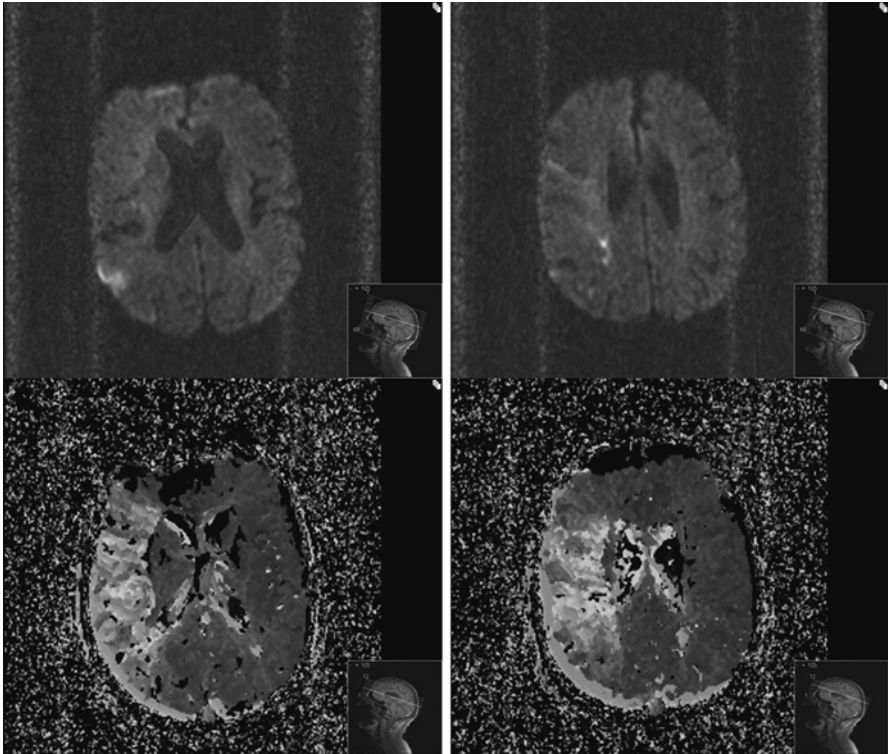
MRI diffusion–perfusion imaging with small area of diffusion positive area noted in right hemisphere suggestive of core infarct. MRI perfusion shows almost the entire right MCA territory at risk with large area of penumbra
